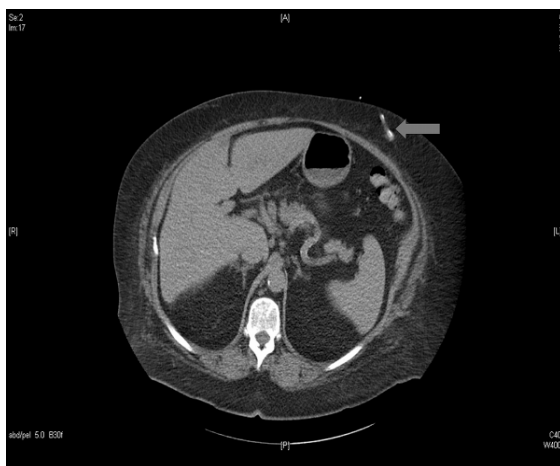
Computed tomography image of abdomen, showing catheter location (arrow).
